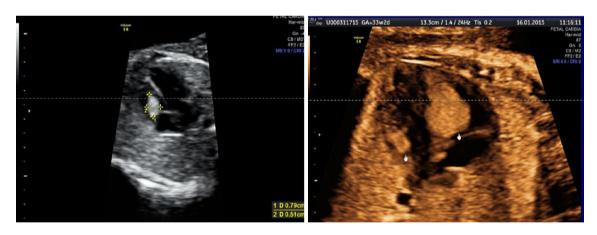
Left ultrasound B-mode images of a cardiac rhabdomyoma measuring 8×5 mm in the *right ventricle* at 23 weeks. *Right* the same tumor increased to 15×14 mm in the *right ventricle*, with the appearance of an additional lesion in the *left ventricle* (Case 1 in Table 1)
